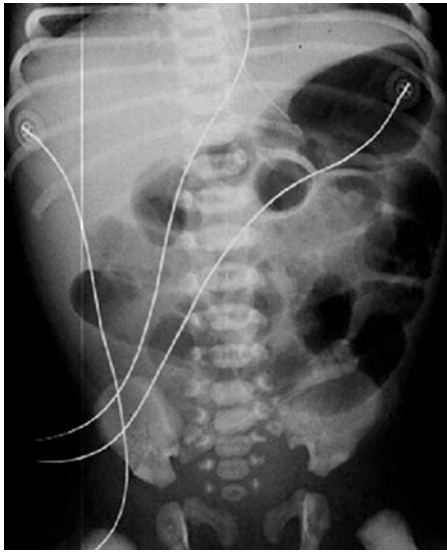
Abdominal X-ray at 24 h of life in infant with jejunal atresia. Proximal dilated loops of small bowel are seen with no gas in distal bowel. From Couture A. Bowel Obstruction in Neonates and Children. In: Baud C, et al. Gastrointestinal Tract Sonography in Fetuses and Children: Springer; 2008, pp 131–251. Reprinted with permission.
